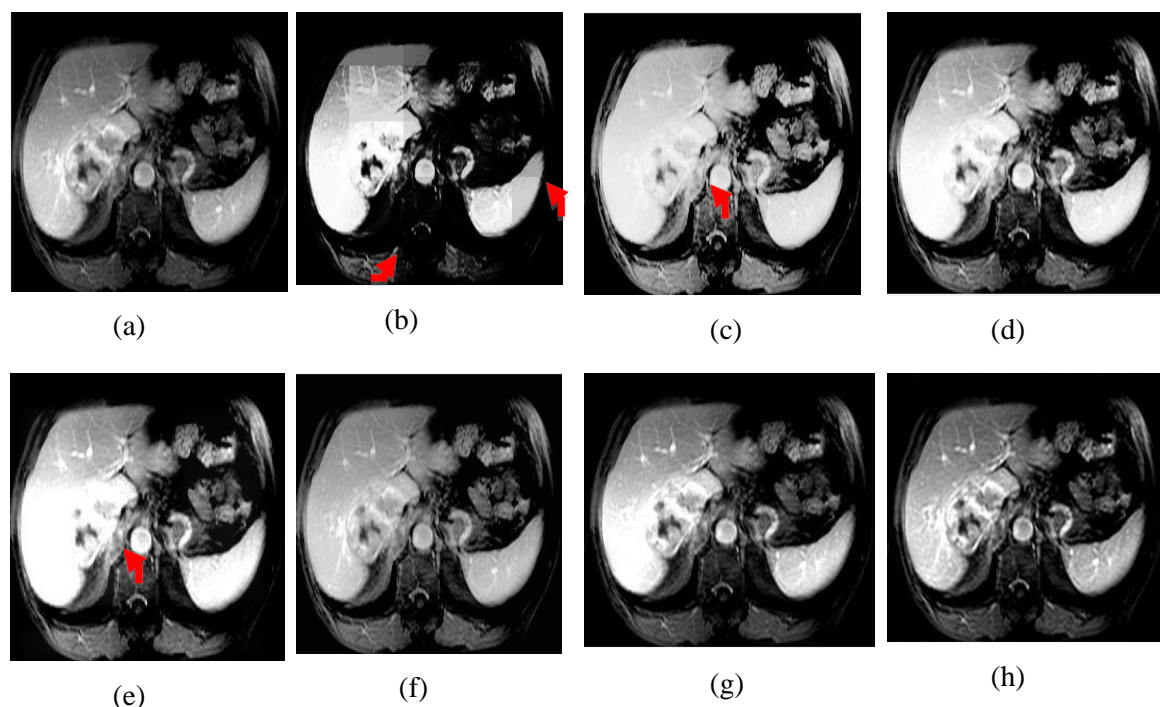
Experiment outcomes of the 'CT-3' Image (a) Original image, (b) S-curve, (c) AGC-DWT, (d) AGC-WHD, (e) GAGC-DWT, (f) EBCHE, (g) TCHE-DWT, (h) Proposed scheme
